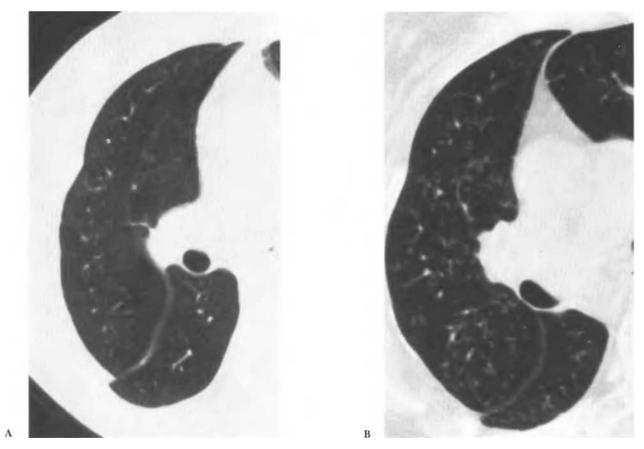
Serial CT scans in a single-lung recipient with bronchiolitis obliterans syndrome. A: Normal CT scan 4 months after transplantation. B: CT scan 1 year later, demonstrating increasing bronchiectasis and parenchymal changes
